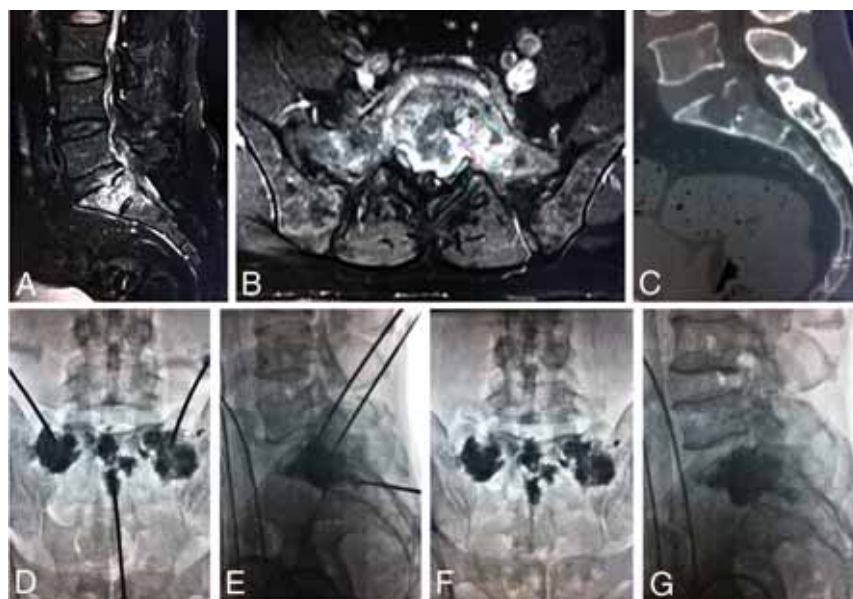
PSP procedure. A–C, Metastatic lesions in the sacral ala and bodies can be seen on enhanced sagittal and axial T1-weighted MR imaging and sagittal reconstruction CT images. D and E, Radiographs obtained during percutaneous cement injection with the patient in the supine position. F and G, After PSP, there is homogeneous and sufficient distribution of bone cement in the lesions.
